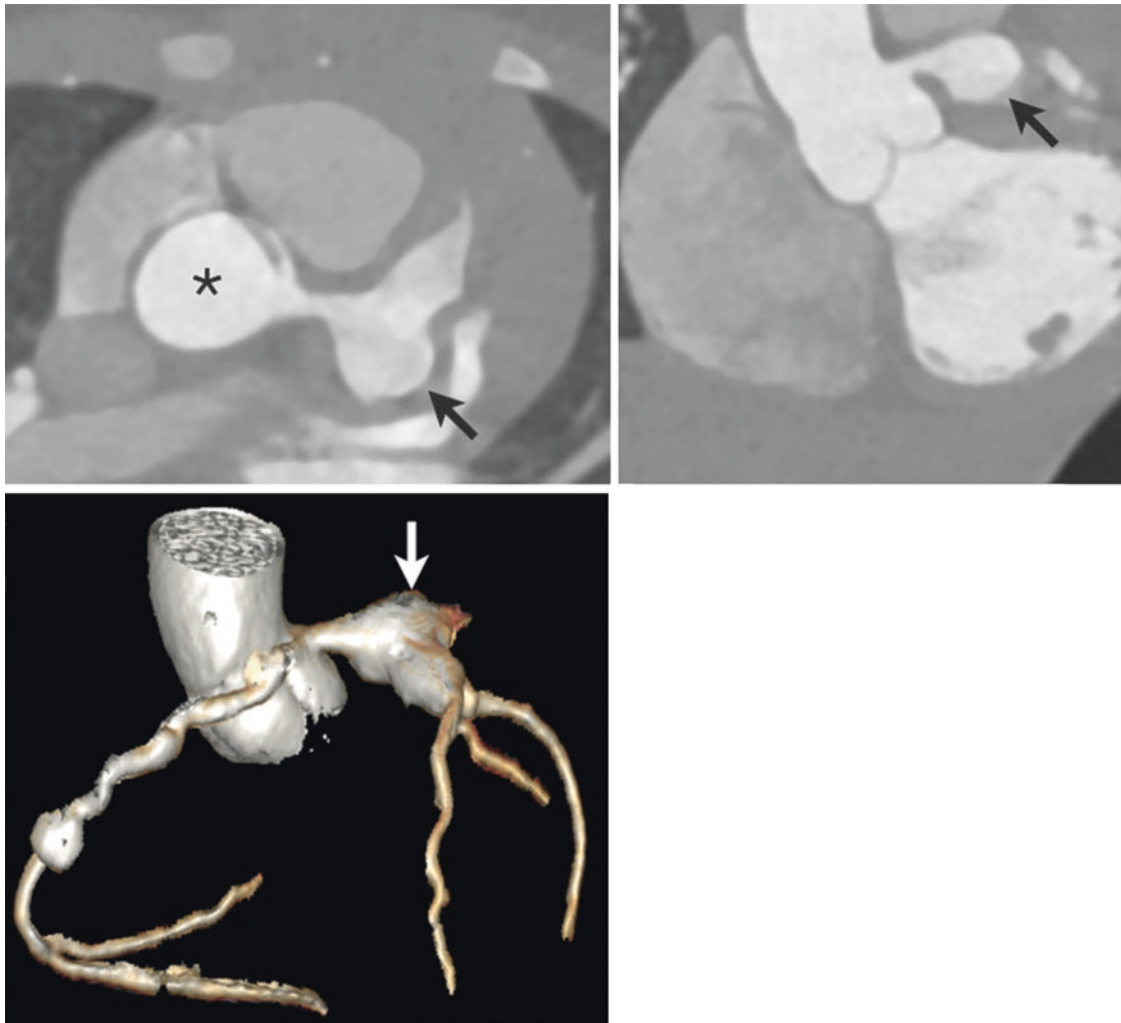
Kawasaki disease with giant left coronary artery aneurysm in a 7-year-old, contrast-enhanced CT. Upper right image (axial view) shows a patent, giant aneurysm of the left main stem (LMS) coronary artery (arrow), aortic root (*). Upper left image shows the LMS in an
